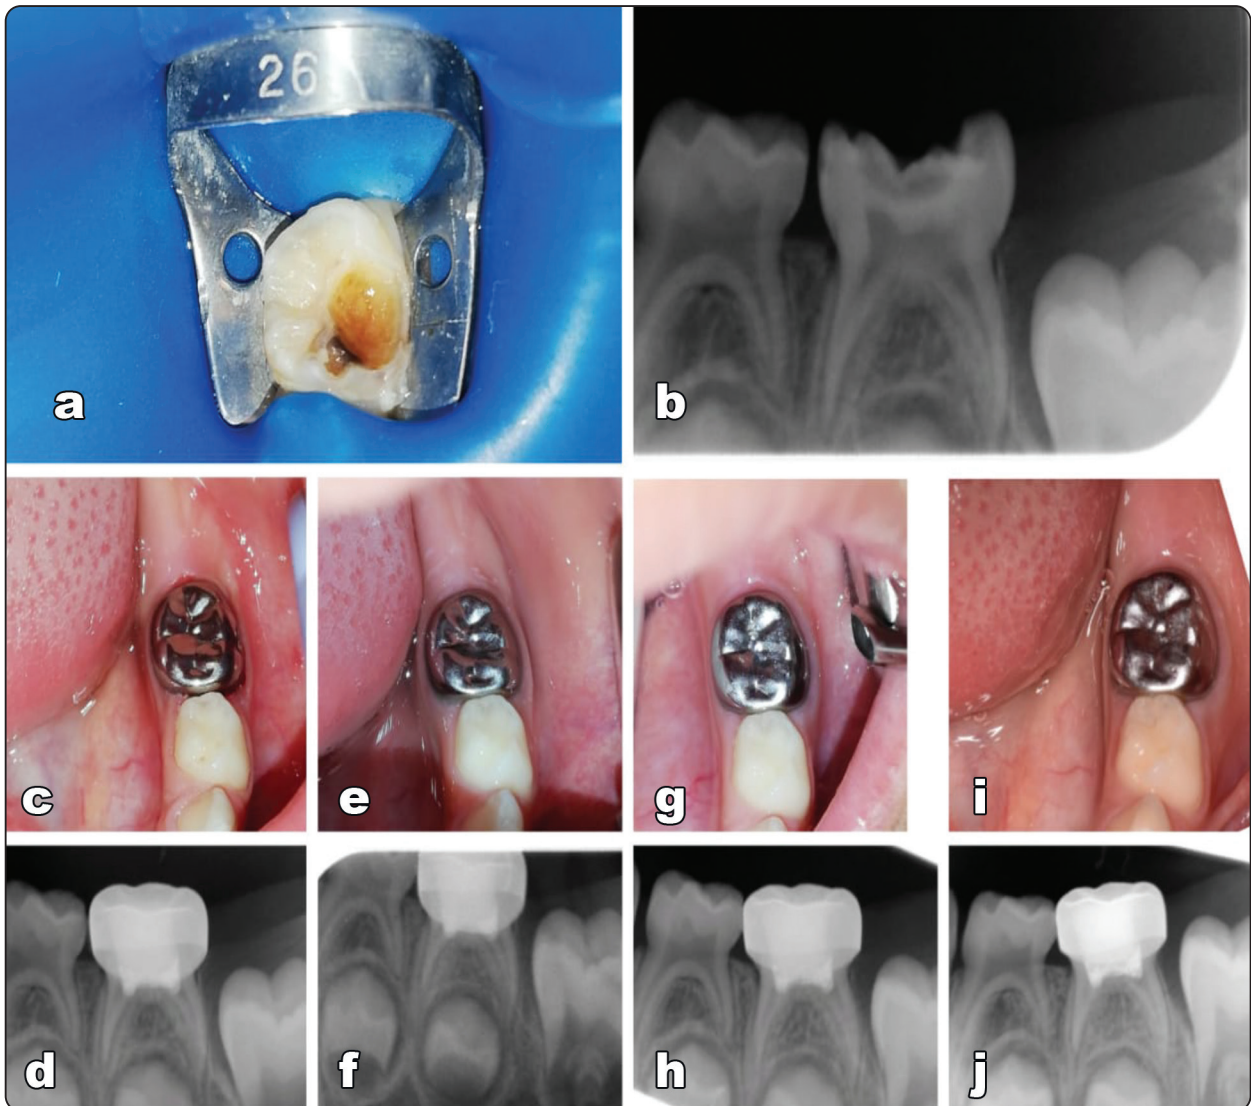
Clinical and radiographic assessment of pulpotomy with MTA a and b: preoperative photo and radiograph, c and d: postoperative photo and radiograph, e and f: after 3 months, g and h: after 6 months, i and j: after 12 months
